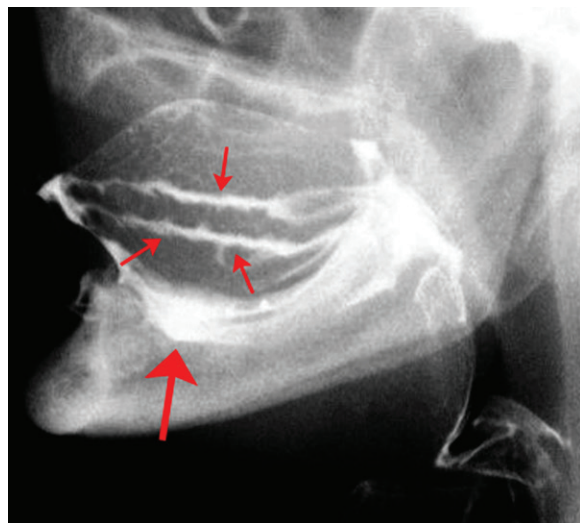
Leakage into the floor of the mouth in a 77-year-old woman. Lateral radiograph of the oral cavity after the swallow shows that contrast material has leaked into the mouth floor (large arrow) and the sulci of the cheeks (small arrows) because of incompetence of the tongue.
